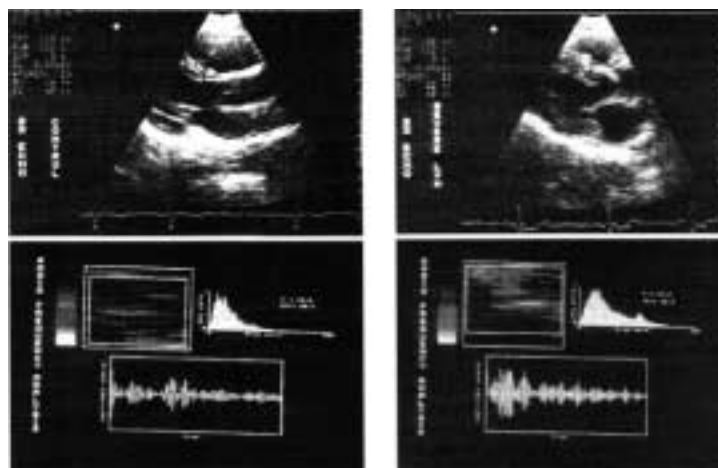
Top: two-dimensional echo image showing a left ventricular long-axis view, with the sample volume positioned on the septum strictly perpendicular to the ultrasound beam in a control (left) and in a hypertensive patient (right) with severe left ventricular hypertrophy. Bottom: relative backscattered radiofrequency signal corresponding to the septum area. There is a frequency gray level histogram (on the x-axis the gray level value using a zero to 255 scale; on the y-axis the frequency of occurrence); the display of the radiofrequency signal in the time domain (on the ordinate, the height of the signal in millivolts; on the abscissa, time in milliseconds). In a hypertensive patient with severe left ventricular hypertrophy (on the right) the echo-reflection pattern is increased in comparison with that of the control (on the left).
